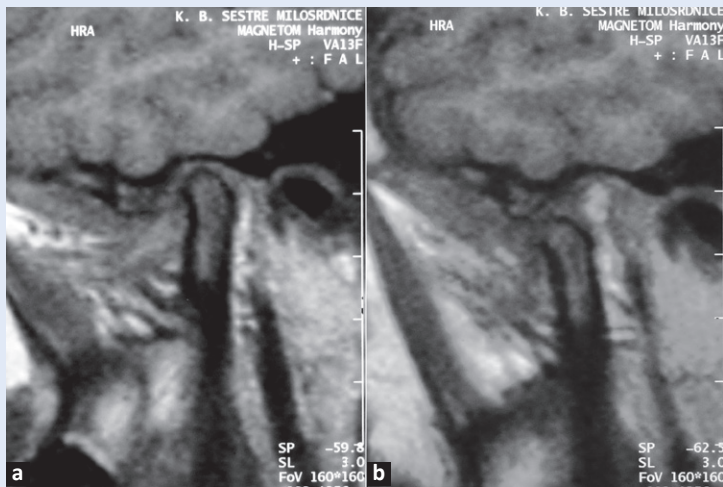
A long-term follow-up by MRI showed condyle in the centric position with reducing disc displacement in the right TMJ
